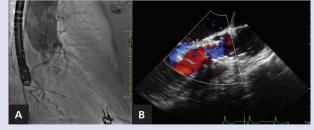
Severe homograft aortic insufficiency in colour Doppler imaging
